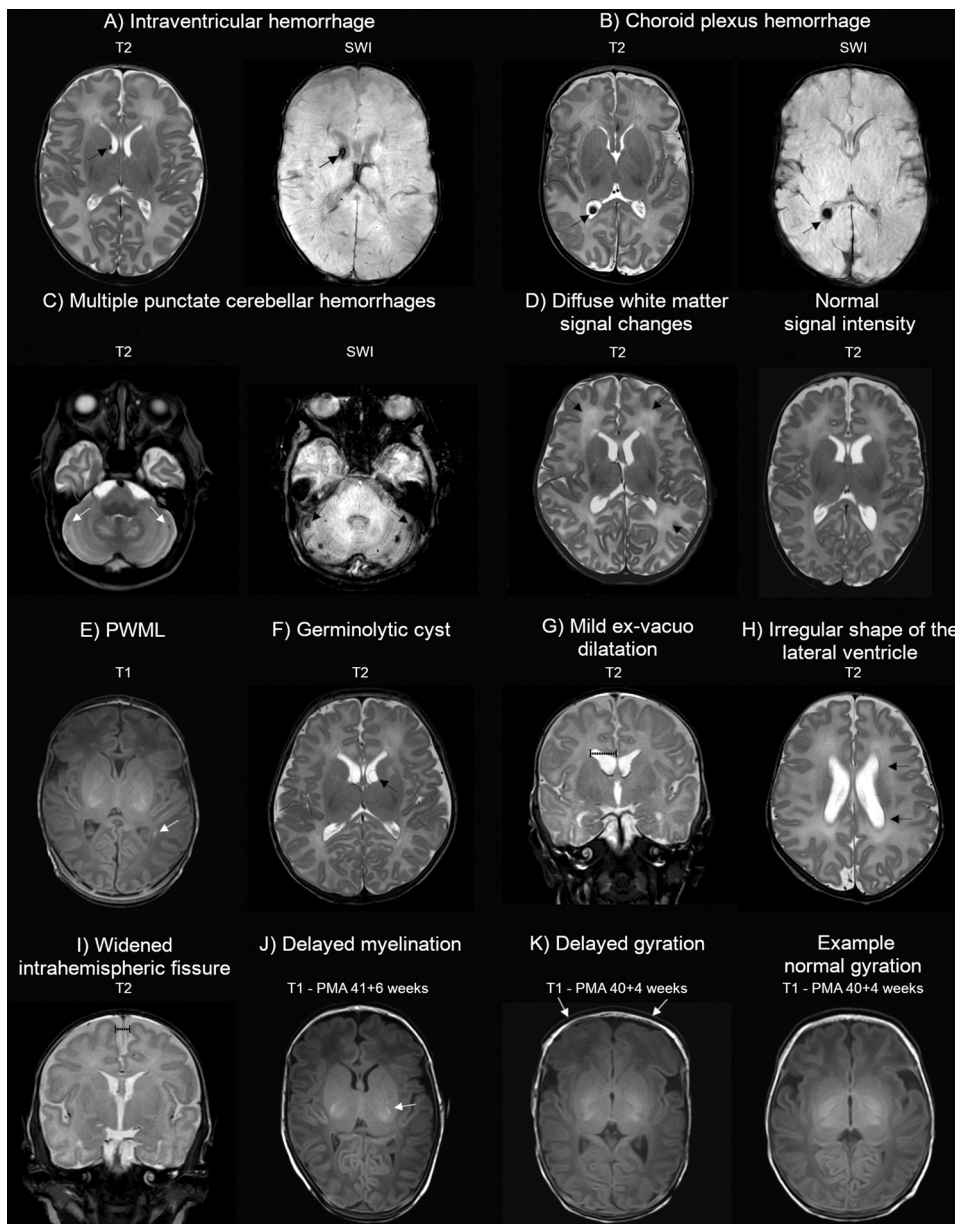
MRI images of mild brain lesions in MLPT infants A) Subependymal hemorrhage/ intraventricular hemorrhage grade I (arrow); B) Choroid plexus hemorrhage (arrow); C) Multiple punctate cerebellar hemorrhages; D) Diffuse white matter signal changes (arrows), for comparison a T2-weighted image with normal signal intensity is added; E) Small PWML (arrow); F) Germinolytic cyst (> 6 mm) (arrow); G) Mild ex-vacuo dilatation, dashed line = measurement of ventricular index H) Irregular shape of the lateral ventricle (arrows); I) Widened interhemispheric fissure, dashed line = measurement of interhemispheric fissure. J) Delayed myelination of the posterior limb of the internal capsule (arrow) in an infant scanned at PMA 41 + 6 weeks; K) T1-weighted image showing delayed gyration, especially in the frontal lobes (arrows), as compared to normal gyration reference images of Barkovitch and Mukherjee [29]. For comparison a T1-weighted image showing normal gyration in another infant, scanned at the same PMA. PMA = postmenstrual age; SWI = susceptibility weighted imaging
